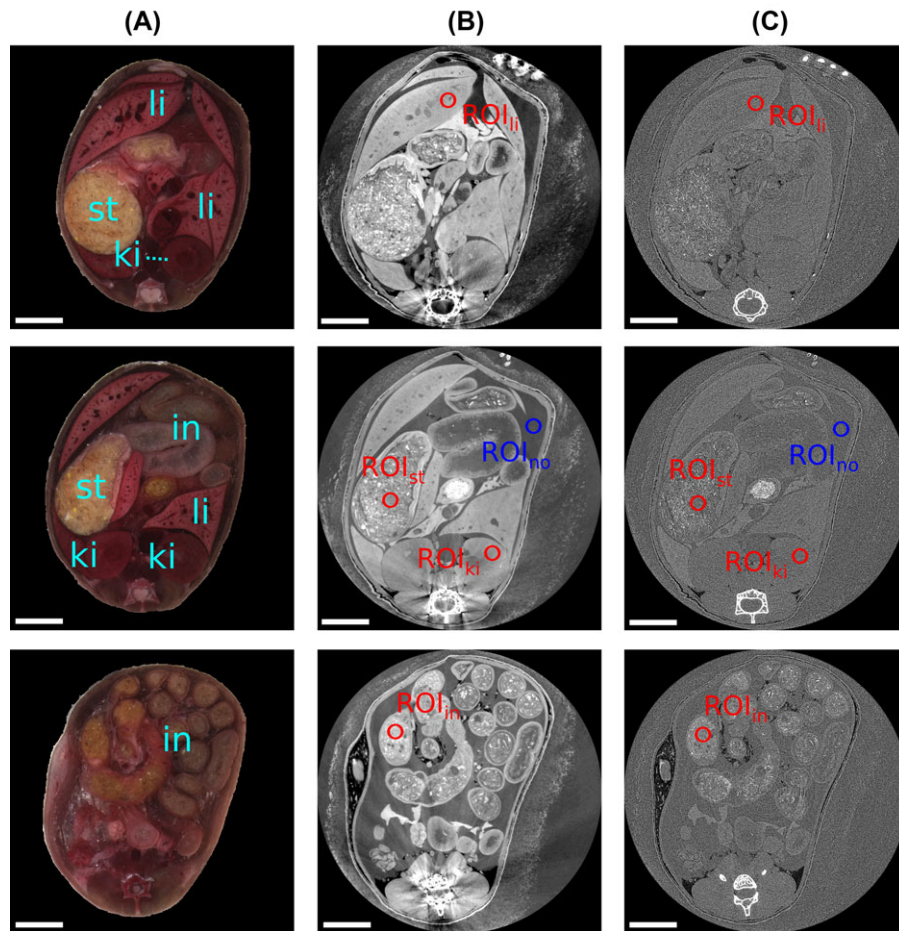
Transverse slices of all imaging modalities at three different positions: (A) cryo-images, (B) phase-contrast CT images and (C) attenuation-based CT images. In the cryo-images, prominent organs are labelled: stomach (st), liver (li), kidney (ki), intestine (in). For the SNR analysis, the employed ROIs of the corresponding organs are indicated by red circles and the noise ROIs is indicated in blue. All images are displayed on a linear greyscale and are windowed for best visual appearance. The scale bar indicates 5 mm.
